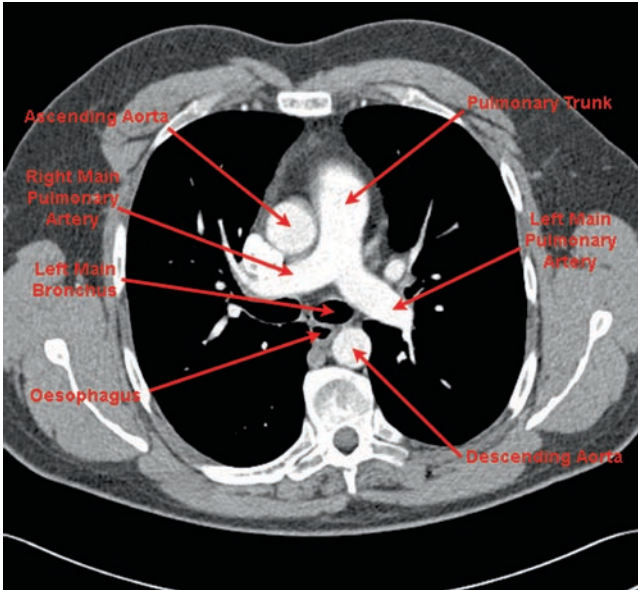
Thoracic CT slice taken at the level of T6 showing the relationship of the esophagus to the trachea/left main bronchus, descending aorta, ascending aorta, pulmonary trunk, and main pulmonary arteries.
